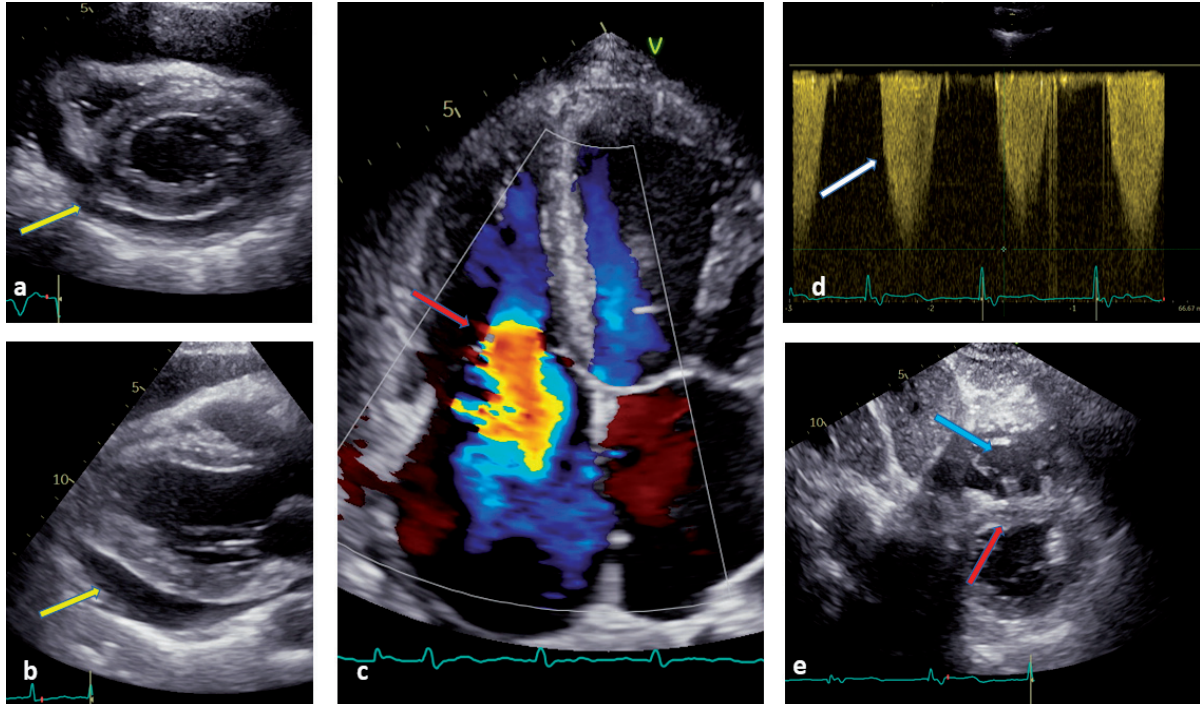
FoCUS images: (a) Parasternal Short Axis View (PSAX) with pericardial effusion – yellow arrow, (b) Parasternal Long Axis View (PLAX) with pericardial effusion – yellow arrow, (c) Apical 4-chamber View (4CH) with severe tricuspid regurgitation – red arrow, (d) Continuous-wave Doppler performing tricuspid regurgitation – white arrow, (e) Dilated right ventricle – blue arrow with a “flattening” of the interventricular septum as a result of high pressure in the right ventricle – red arrow
